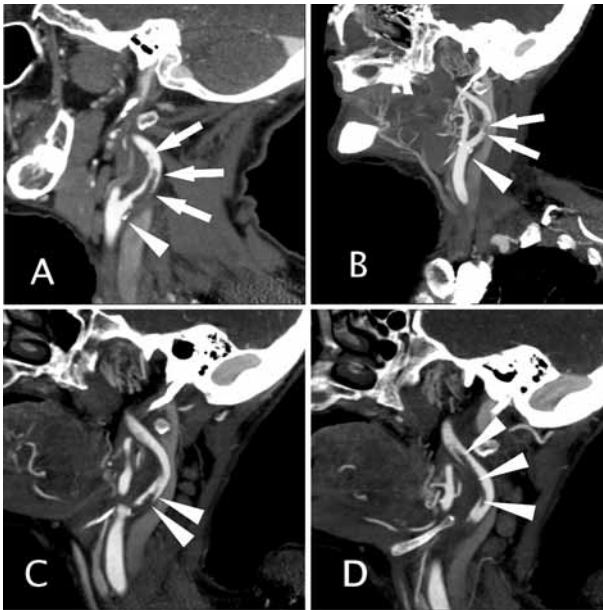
(A, B) CT angiography showing a 3 cm large mobile thrombus (arrows) in the right internal carotid artery overlying a partly calcified atheromatous plaque (arrowhead). (C, D) Control CT angiography showing an extension of the thrombus to 7 cm (arrowheads).
